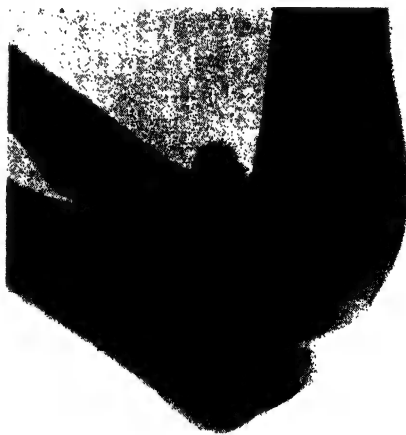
Comminuted fracture of the head of the radius. X-ray showing forward dislocation of the head of the radius, and how the acute flexion of the elbow has produced the deformity. Treatment of the elbow in flexion would tend to maintain this.
